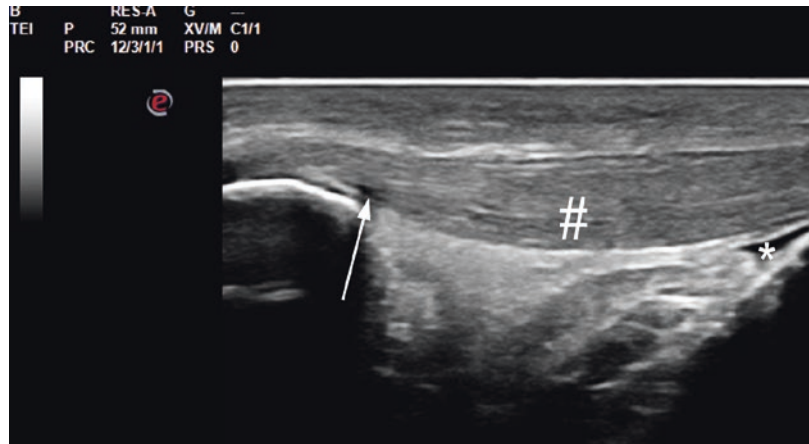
Achilles tendinopathy. (a) Clinical aspect; difference between the thickened and swollen injured tendon (right side, white arrow) and the noninjured tendon (left side). (b–e) High-definition ultrasound study; transverse
